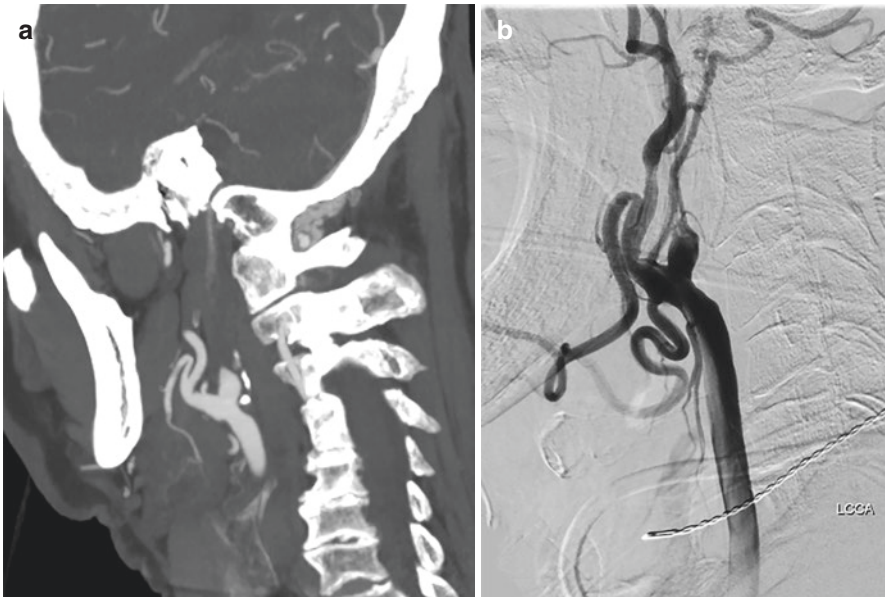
CTA (panel a) and DSA (panel b) images demonstrating an acute carotid occlusion. Note the tapered stump in both images, indicative of an acute occlusion
